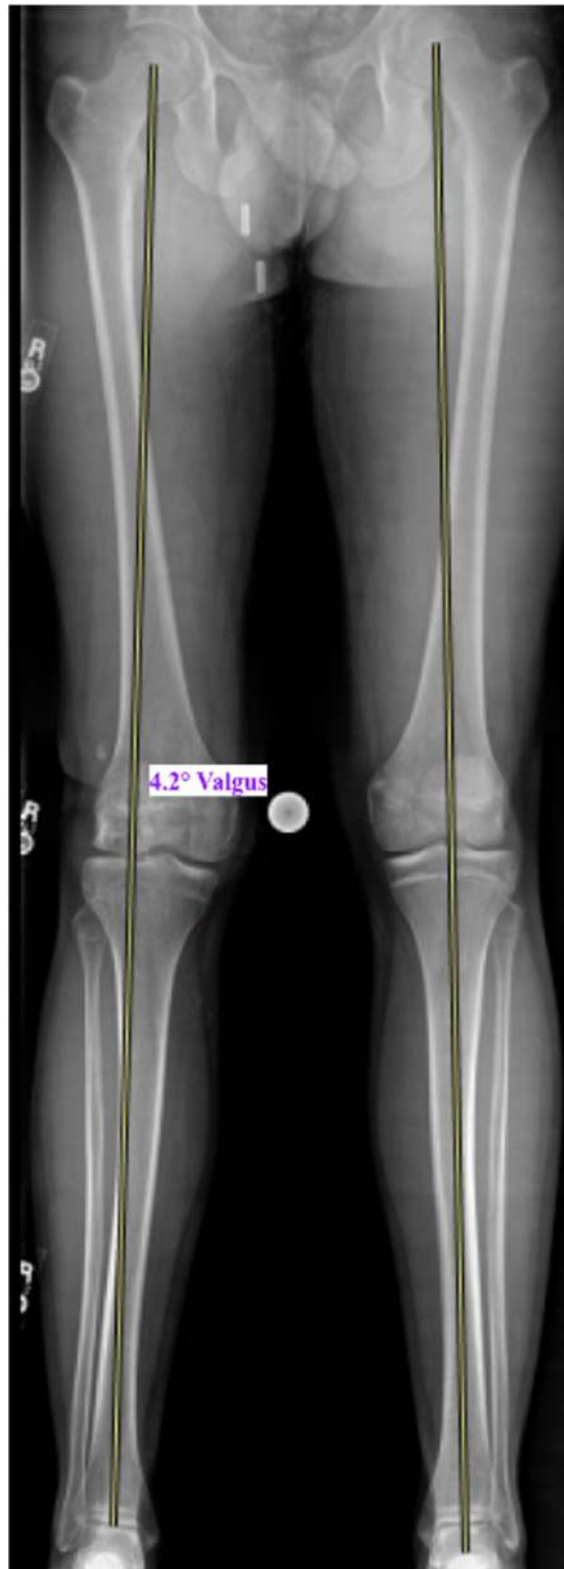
Standing long-leg anteroposterior radiographs. Undistributed axial loading is a risk factor for osteochondritis dissecans. Lateral femoral condyle lesions are also a risk factor, especially in patients with valgus malalignment. Because of these known risk factors, concomitant management of coronal malalignment should be considered to optimize healing. Standing long leg anteroposterior view radiographs allow for measurement of the patient's mechanical weightbearing axis and hip-knee-angle (HKA), which tells us whether the patient has varus or valgus malalignment. For this patient, a line is drawn from the center of the femoral head to the center of the tibiotalar joint to find the mechanical weightbearing axis. In healthy adults, the HKA is between 1° valgus and 3.2° varus. In this patient, the HKA is 4.2° valgus, indicating that the patient is in valgus malalignment and bears weight through the lateral compartment of the knee. Therefore, management of the patient's malalignment with distal femoral osteotomy should be considered.
